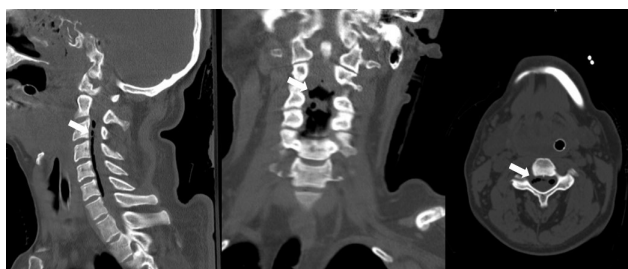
Computed Tomography (CT) scan of cervical pneumorrhachis-sagittal, coronary, and axial view. The white arrows point to the intraspinal air.
